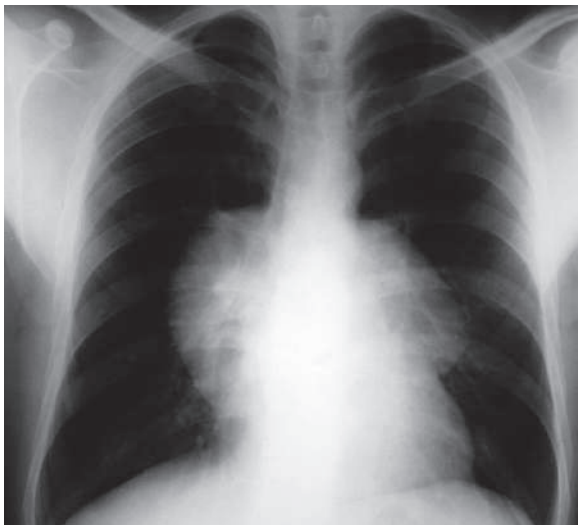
Posteroanterior plain chest radiograph of a patient with NHL shows bilateral enlarged, potato-like hilar lymphadenopathy
